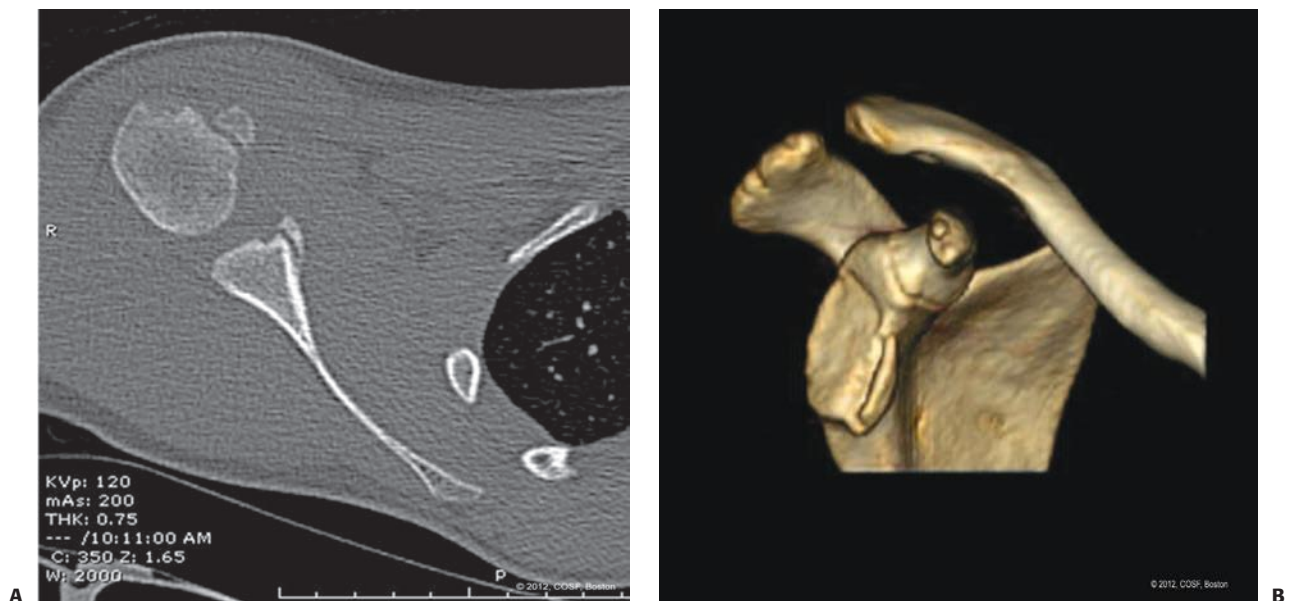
Computed tomography (CT) images of a 13-year-old male after traumatic anterior shoulder dislocation. Axial images (A) and three-dimensional reconstruction with subtraction of the humeral head (B) depict an anterior glenoid fracture (bony Bankart lesion).
